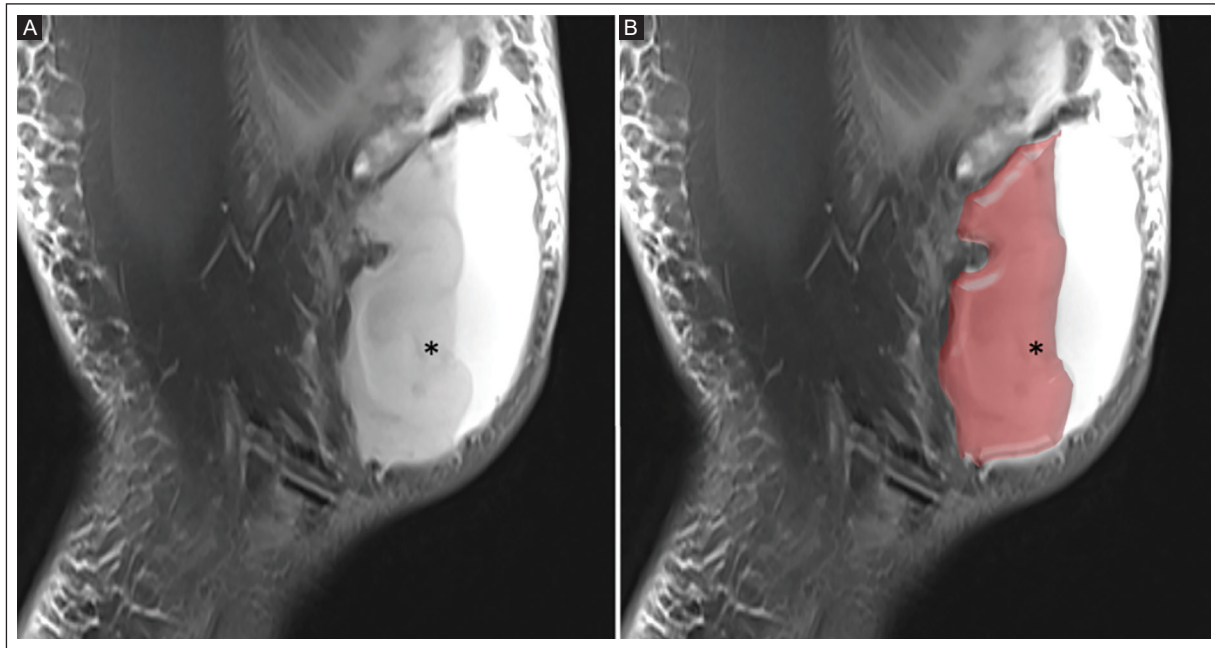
A-B: sagittal proton density-weighted knee MRI with fat suppression in a 22-year-old man demonstrates a markedly distended superficial prepatellar bursa containing a heterogeneous fluid collection with fluid-fluid levels, showing dependent hypointense sedimented components and nondependent hyperintense fluid signal superiorly (asterisks), consistent with hemorrhagic bursitis. The bursal extent is highlighted in red.
